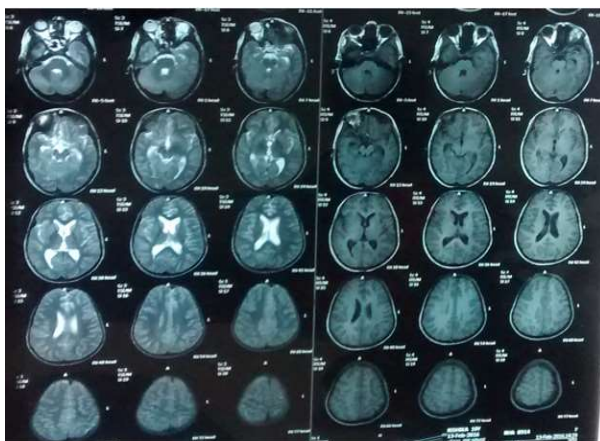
MRI brain showing bilateral posterior occipito parietal oedema
